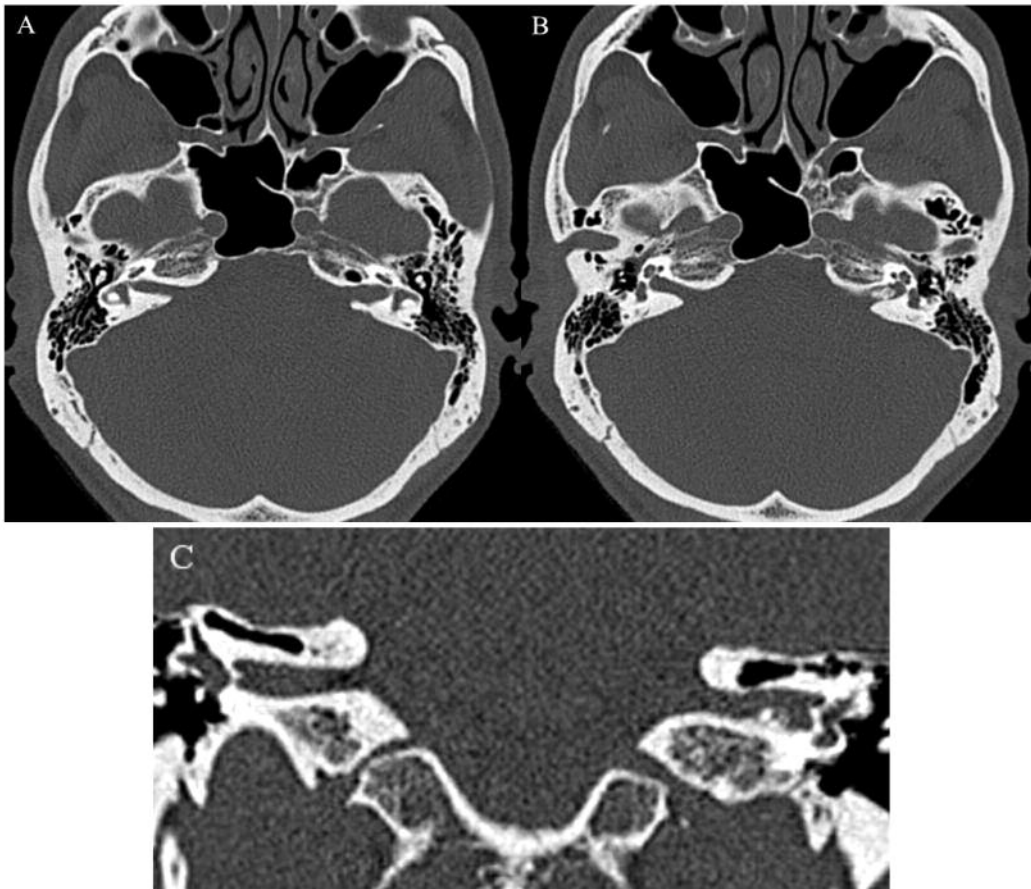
High-resolution CT of the internal auditory canal (ICA). (1A) Axial view shows a slight widening of the left ICA compared with the right. (1B) Axial view shows some calcifications in the left ICA. (1C) Coronal view shows the calcifications in the fundus of left ICA.
